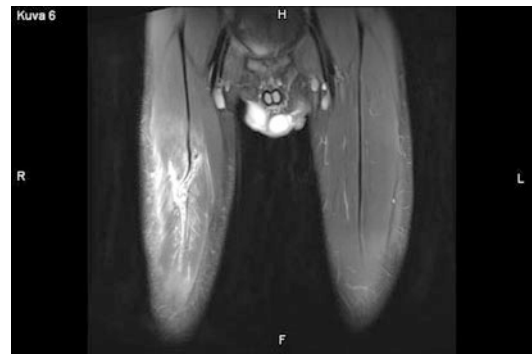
An MRI of the rectus femoris central tendon rupture
